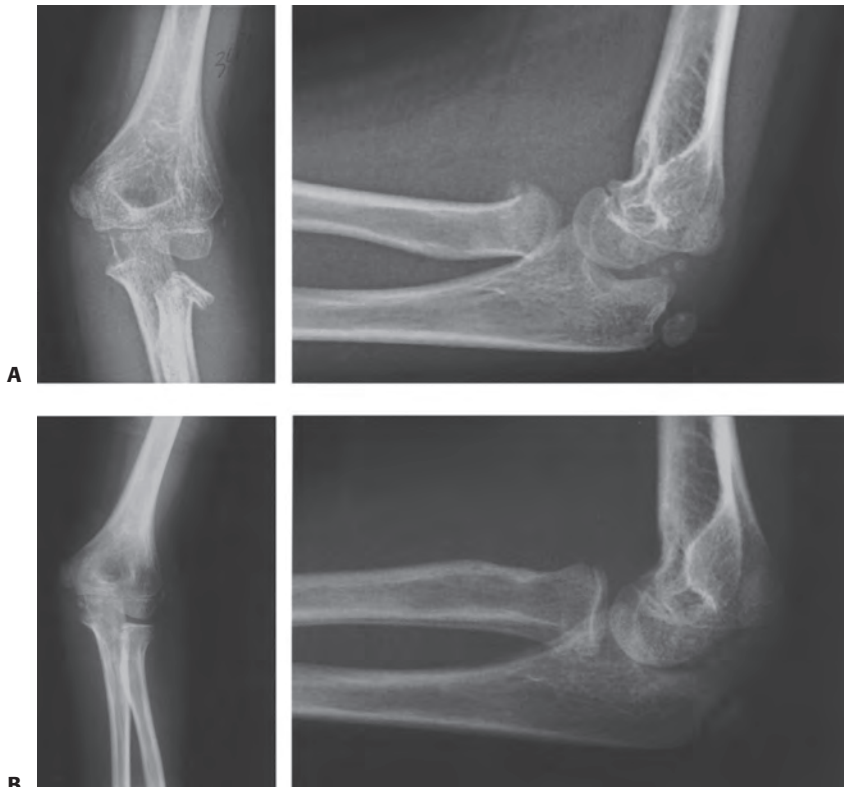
A: Preoperative anteroposterior and lateral radiographs of left elbow of a 9-year-old girl showing 34 degrees of angulation and 50% displacement. B: Anteroposterior and lateral radiographs of the fracture 5 months postreduction showing maintenance of reduction with good callus formation. (From Monson R, Black B, Reed M. A new closed reduction technique for the treatment of radial neck fractures in children. *J Pediatr Orthop.* 2009;29(3);243–247.)
